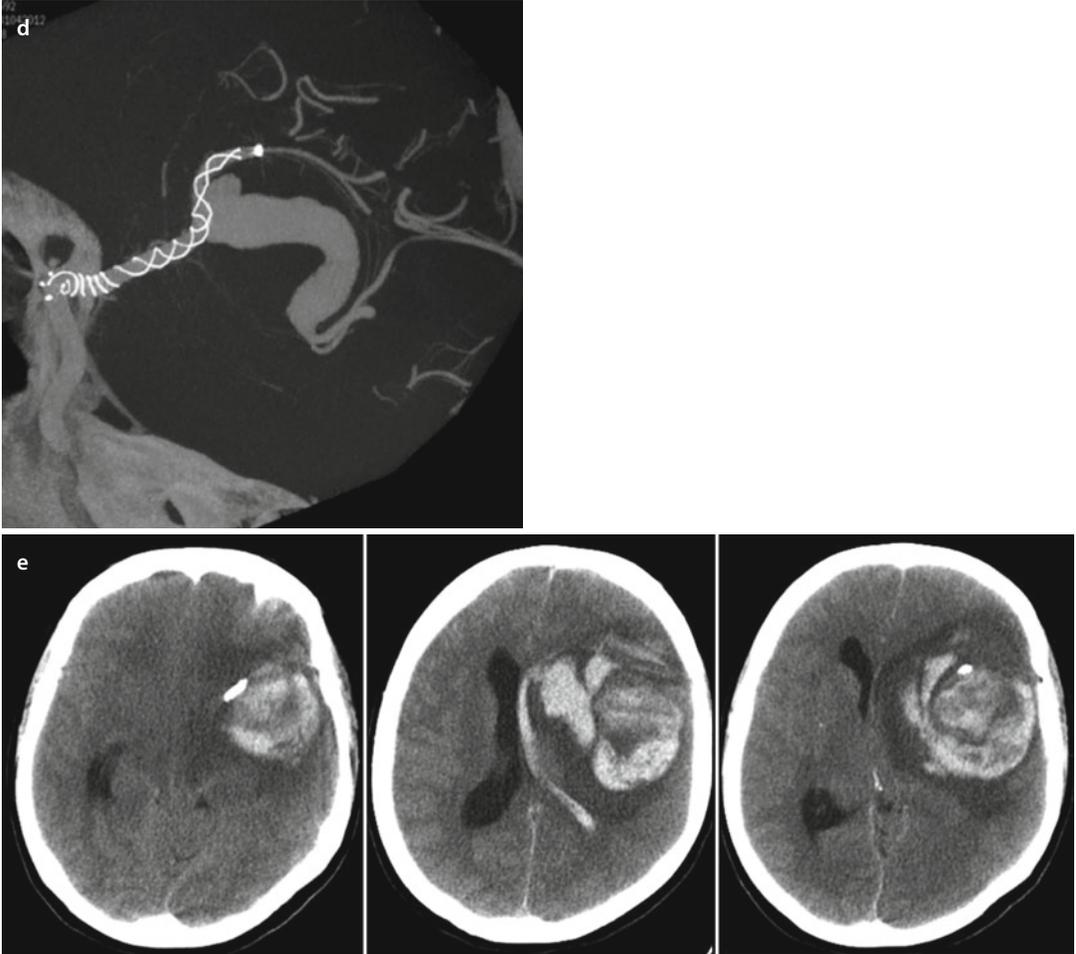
(continued) (d) IV VASO[®] CTA at 1½ months reveals partially thrombosed GIA with serpentine configuration of the residual lumen extending to the MCA lower trunk with a patent upper trunk. The patient is asymptomatic. (e) Four months later, the patient had sudden headache, altered sensorium, and became comatose. NECT revealed parenchymal and intraventricular hemorrhage with adjacent mass effect and sub-falcine herniation. The patient succumbed to this episode
